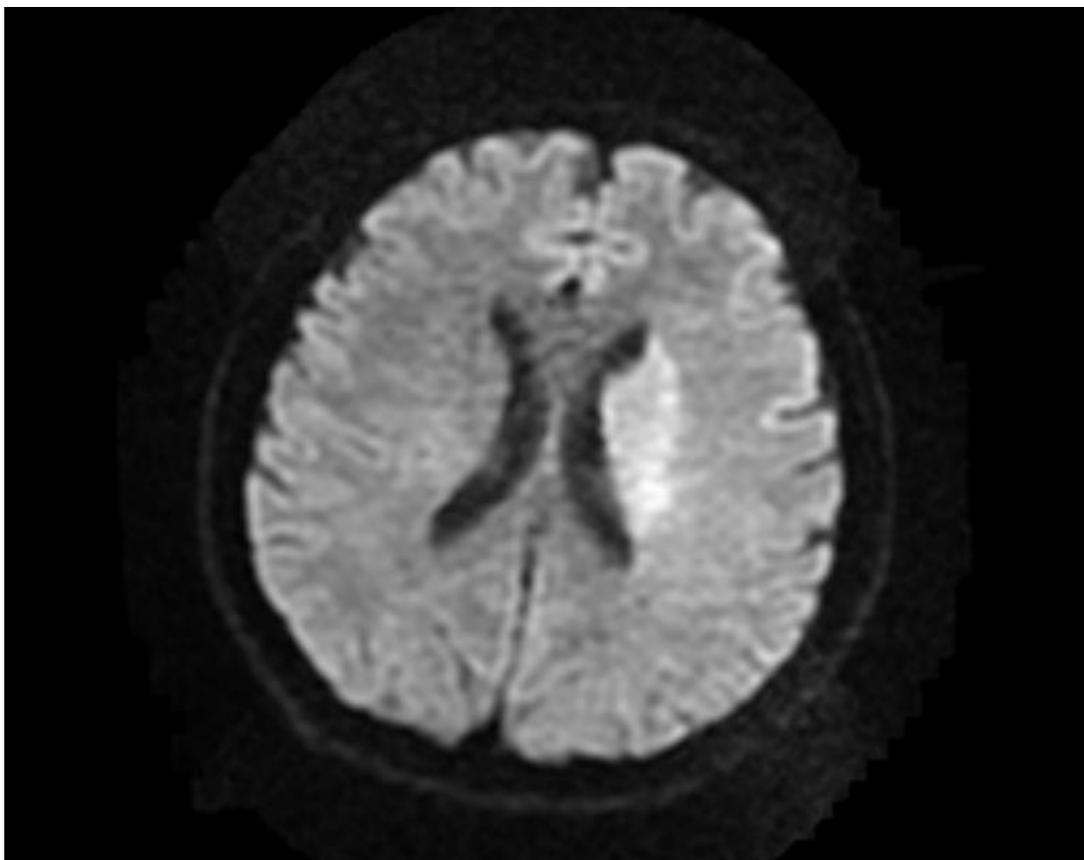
DWI-MRI brain axial image five hours after installation of the motor deficit.
